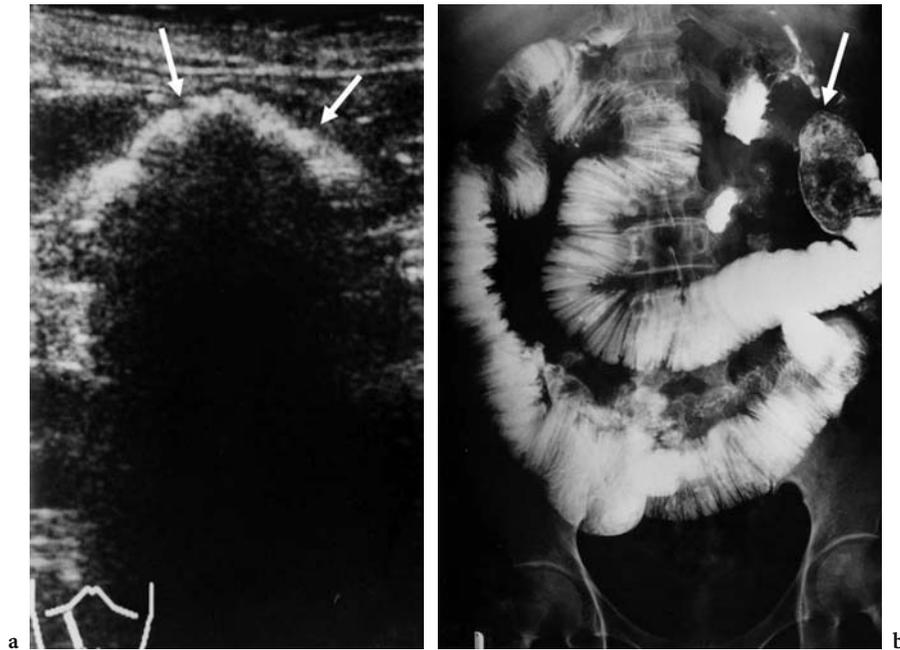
Phytobezoar in the jejunum. a Sonogram of upper abdomen shows hyperechoic, arc-like echo with clear acoustic shadow within a loop of the jejunum (*arrows*). Bowel loops proximal to the bezoar are dilated and filled with fluid. b Small bowel follow-through examination shows a large intraluminal filling defect at the end of the dilated jejunum, representing bezoar (*arrow*)
